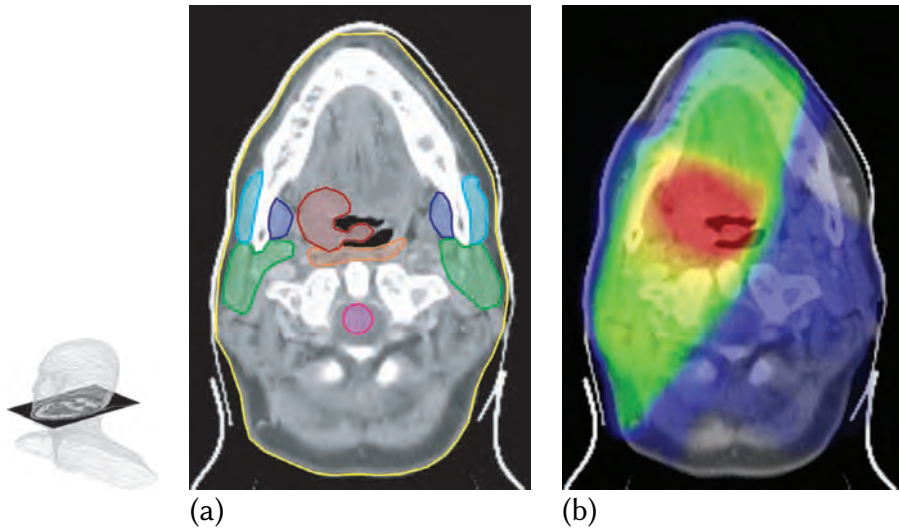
CT image of a patient with head and neck cancer. The leftmost image represents the orientation of the slice inside the head of the patient. The CT scan was used to (a) identify the tumor ■, and important organs, such as parotid glands ■, spinal cord ■, constrictor ■, pterygoid ■ and masseter ■ muscles, and (b) to design a radiation therapy treatment plan. In the dose distribution in (b), hot colors indicate a high dose, while cold colors indicate a low dose.
